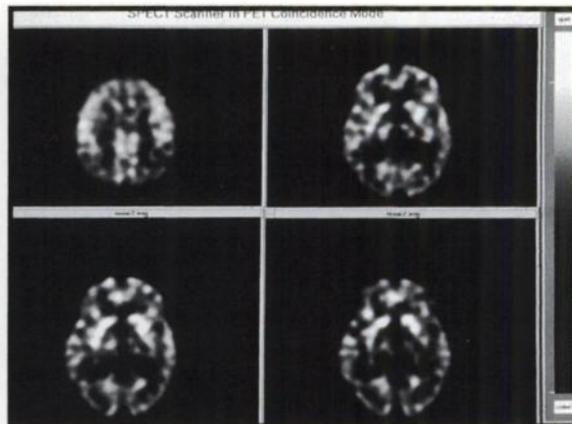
These high-resolution [^{18}F] FDG images of the brain were cited as the "Image of the Year." A "SPECT" scanner was used in a coincidence detection mode.
